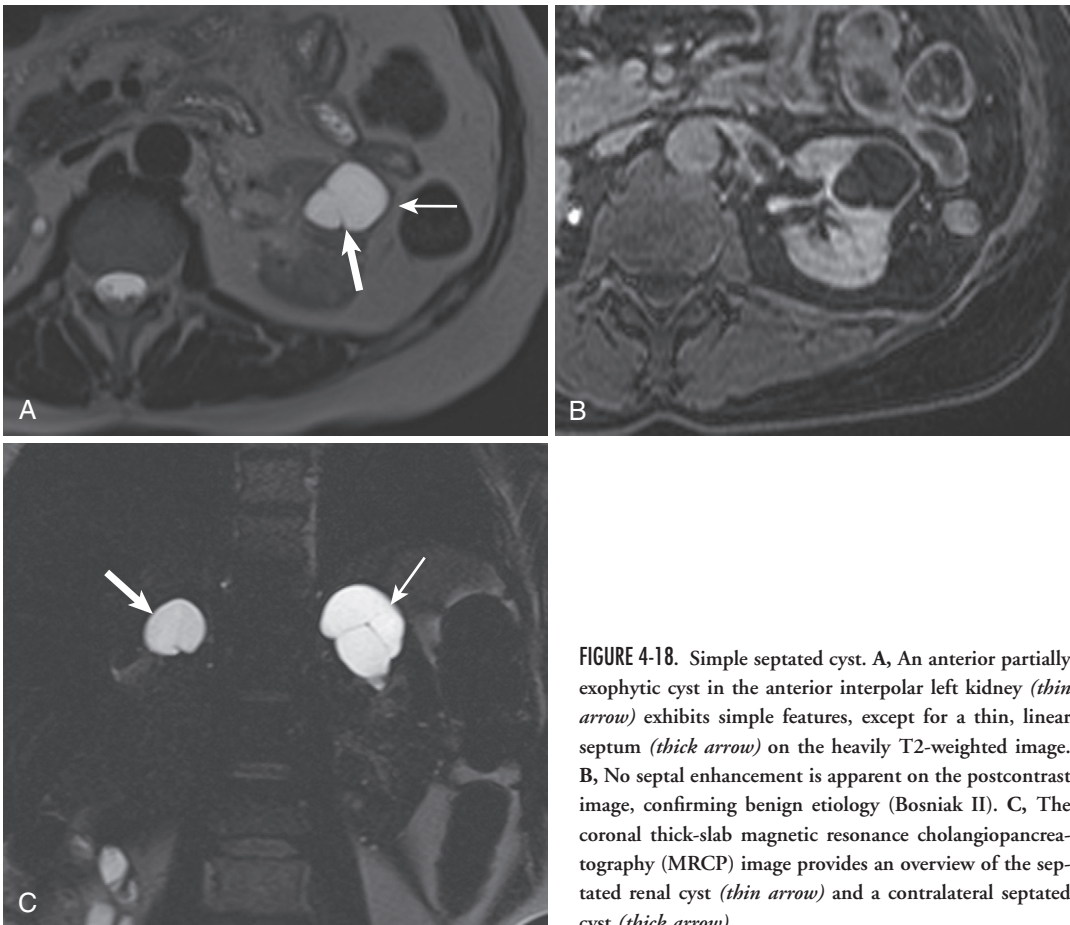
Simple septated cyst. A, An anterior partially exophytic cyst in the anterior interpolar left kidney (*thin arrow*) exhibits simple features, except for a thin, linear septum (*thick arrow*) on the heavily T2-weighted image. B, No septal enhancement is apparent on the postcontrast image, confirming benign etiology (Bosniak II). C, The coronal thick-slab magnetic resonance cholangiopancreatography (MRCP) image provides an overview of the septated renal cyst (*thin arrow*) and a contralateral septated cyst (*thick arrow*).
